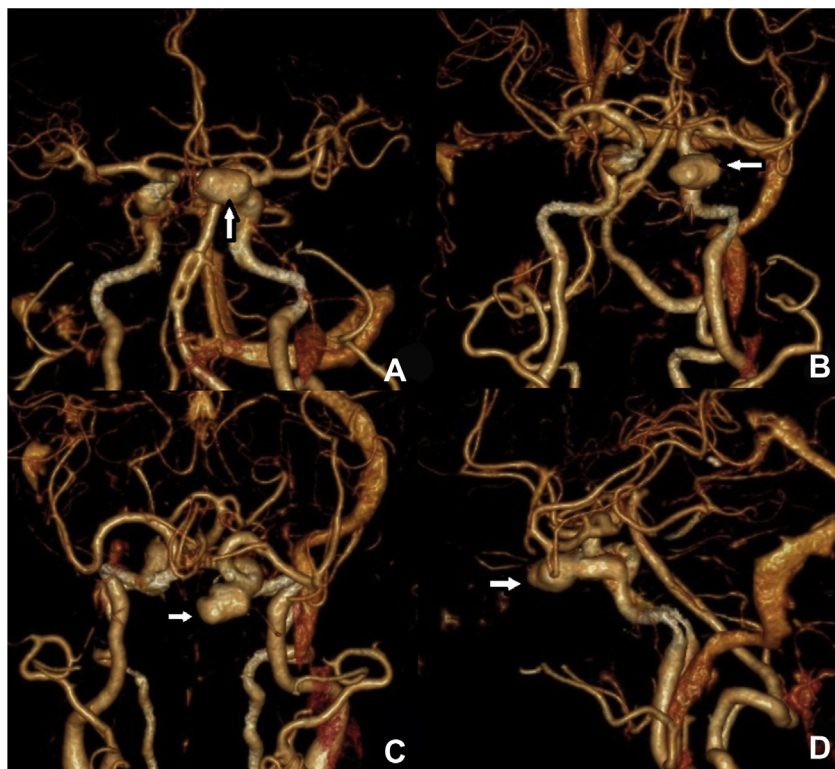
Preoperative 3-dimensional computed tomography angiography shows a saccular aneurysm of cavernous segment of the left internal carotid artery (arrow) projecting anteromedially. (A) Anteroposterior, (B) anterosuperior, (C) superior and (D) left lateral view.
